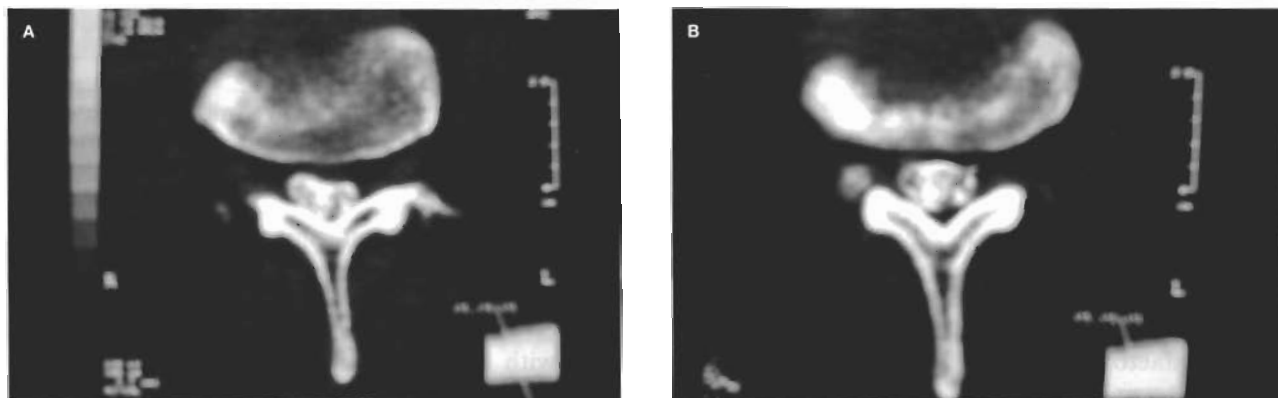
(A) Right herniated disc L3-L4. (B) The herniation has completely disappeared at CT follow up four months after oxygen-ozone treatment.
